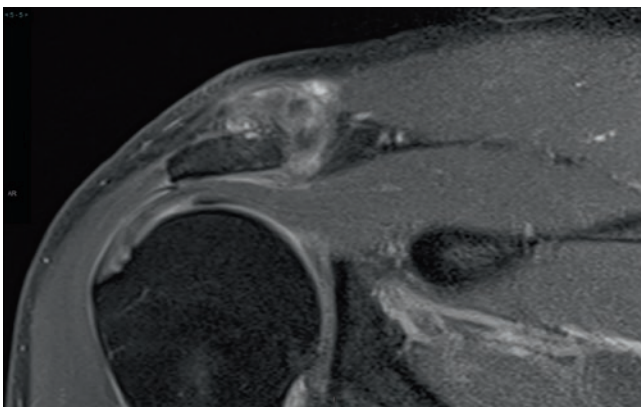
Coronal oblique T2-weighted fat suppressed image showing supraspinatus partial thickness undersurface tear, and acromioclavicular joint degenerative changes with inferior osteophytes
